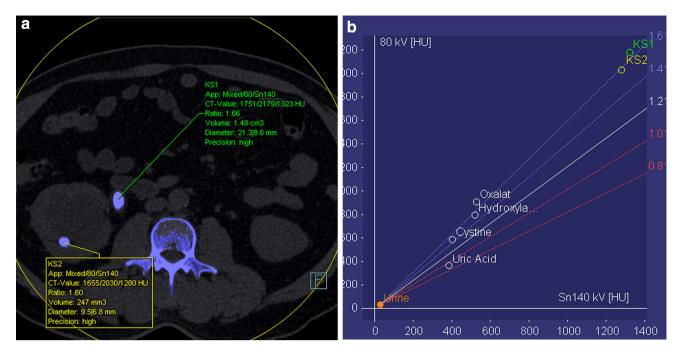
A 44-year-old male presented with right flank pain. Dualenergy CT KUB showed an obstructing right pelviureteric junction stone and a non-obstructing right renal stone. a In analysis of stone composition, post-processing software assigns colour to the stones
